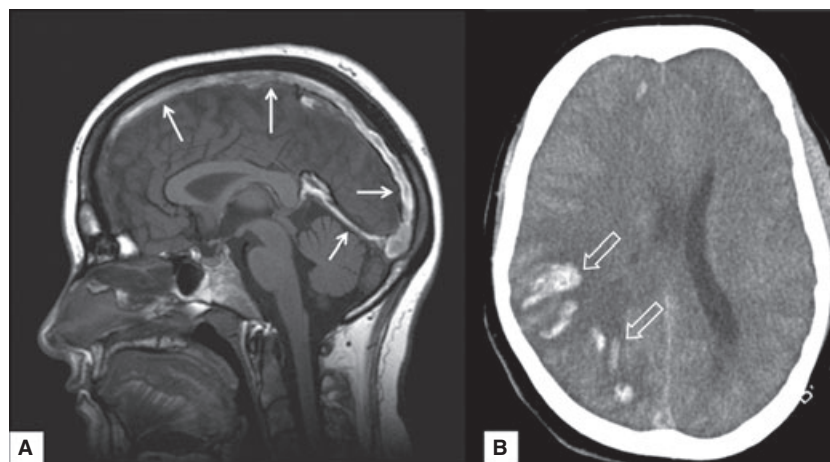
(A) T1 weighted mid-sagittal magnetic resonance imaging (MRI) showing a thrombus located in the superior sagittal sinus and straight sinus (white arrows). (B) Computed tomography (CT)-scan of a typical venous infarct of the right cerebral hemisphere, with areas of hemorrhage (open white arrows) within a hypointense area of focal edema.
